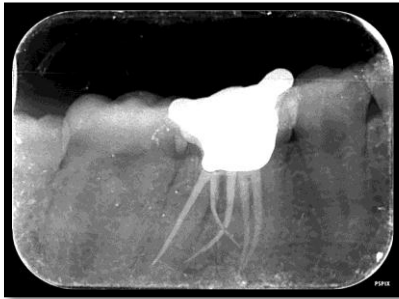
Fig- g – Digital radiograph after endocrown cementation Fig h- 6 month follow up
